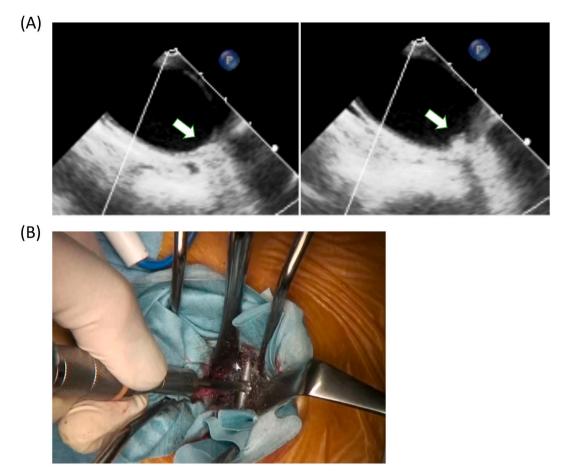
(A) Transesophageal echocardiography of the descending aorta prior to our operation. The arrows in the two panels point to the same place. Each time the aorta beat, the tip of the screw was pressing against and retreating from the arterial wall.(B) The metal rod running through the screw was drilled and broken off. With this technique, steps must be taken to mitigate the risk of vibration transmission from the drill to the screw during screw removal.
